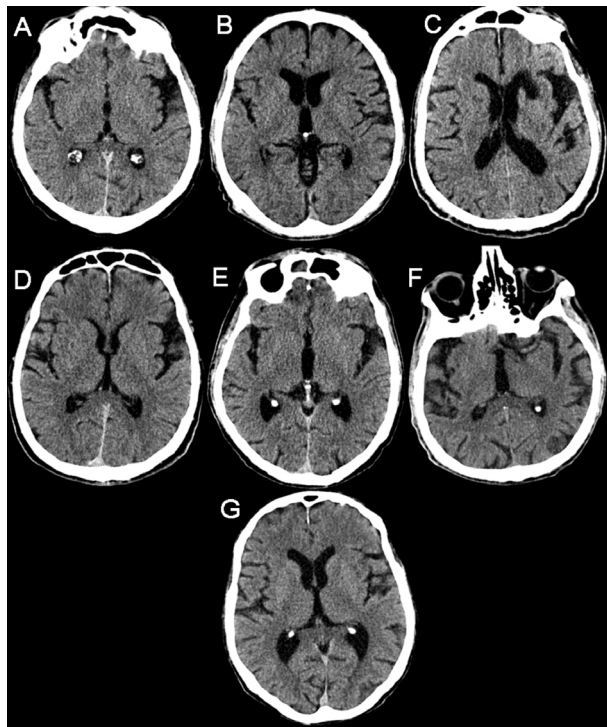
CT scans showing structural alterations in several areas in the brain of haloperidol-treated patients: (A) Left temporal lobe atrophy, posterior ventriculomegaly, pineal gland and choroid plexus calcifications; (B) Posterior ventriculomegaly, bilateral temporal lobes and cerebellum atrophy; (C) Severe ventriculomegaly and left temporal lobe atrophy; (D) Left temporal lobe atrophy, ventriculomegaly, cerebellum atrophy; (E) Left temporal lobe atrophy, posterior ventriculomegaly, cerebellum atrophy, pineal gland and choroid plexus calcifications; (F) Massive right temporal lobe atrophy, cerebellum and left posterior lobe atrophy, choroid plexus calcifications; (G) Bilateral temporal lobes atrophy, posterior ventriculomegaly, cerebellum atrophy, choroid plexus calcifications, minimal frontal atrophy.
